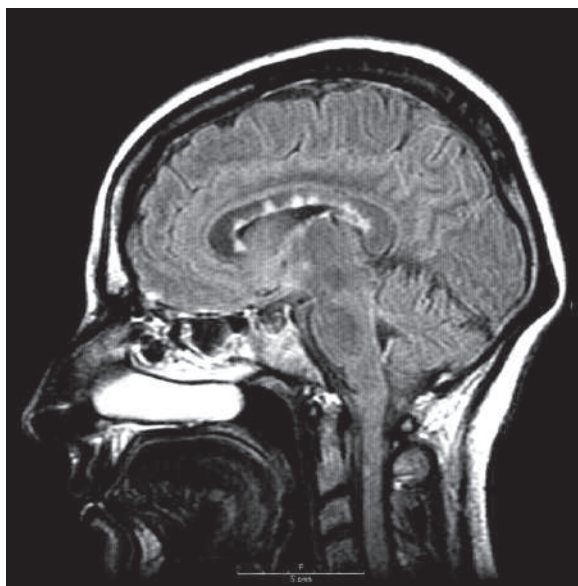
Sagittal FLAIR brain MRI shows multiple hyperintense lesions within the corpus callosum starts from the inferior peripheral surface toward the center (Dawson's fingers)
